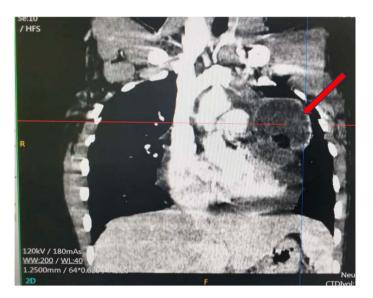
CT scan showing intrapericardial mass (red arrow).
